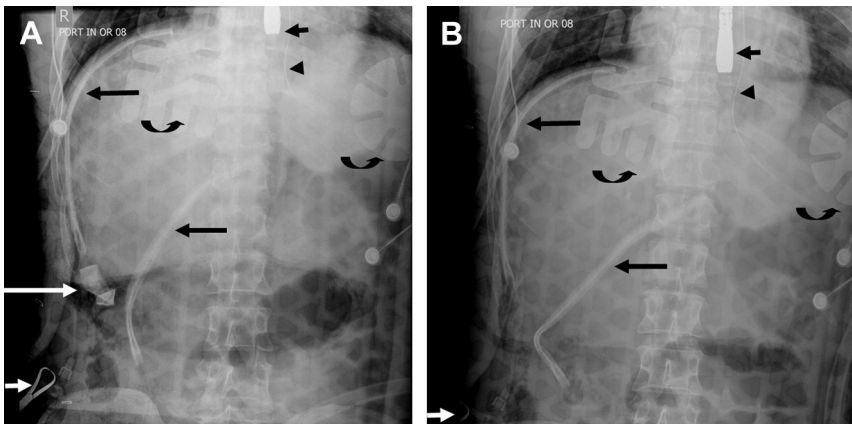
Retained sponge identified on intraoperative radiograph. (A) Radiograph obtained at the end of laparotomy because of a mismatch in sponge count shows multiple radiopaque densities: an esophageal Doppler probe (*short black arrow*), a nasogastric tube (*black arrowhead*), 2 drains (*long black arrows*), several overlying external defibrillator/pacer pads (*curved black arrows*), clamp (*short white arrow*), and a radiopaque marker within a sponge (*long white arrow*) in the right mid abdomen. (B) Subsequent radiograph after removal of the sponge shows all previously noted radiopaque densities except for the radiopaque marker within a sponge.
